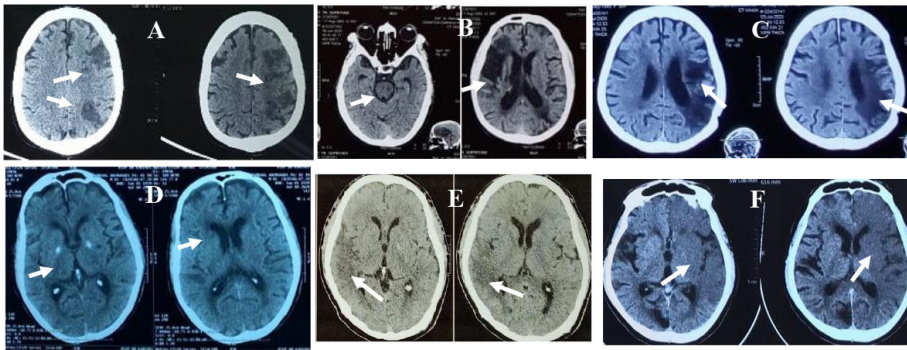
Brain CT scan of the patients. A: large infarction in left frontal and parietal lobe. B: infarction in right frontoparietal lobe, right posterior horn of internal capsule, left parietal lobe, and left paramedian pontine. C: large infarction in temporoparietal lobe, bilateral corona radiata. D: infarction in right caudate nucleus and thalamus, old infarction in left caudate nucleus, thalamus, lentiform nucleus and right external capsule. E: large infarction in right temporoparietooccipital lobe. F: large infarction in left frontotemporoparietal lobe (MCA territory).
